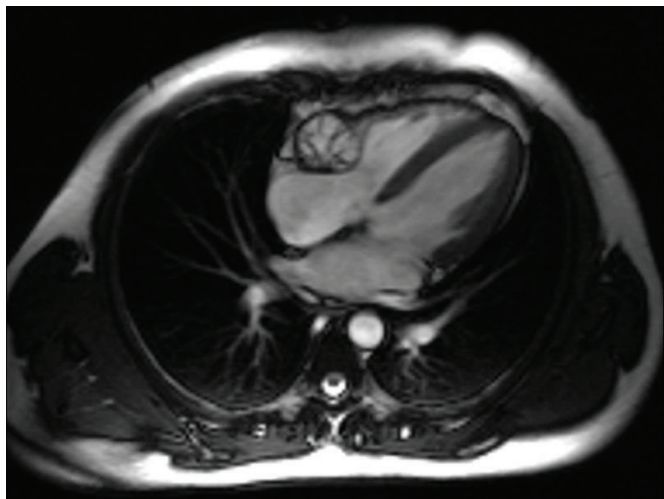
Magnetic resonance imaging of a sagittal section of a cardiac hydatid cyst.
